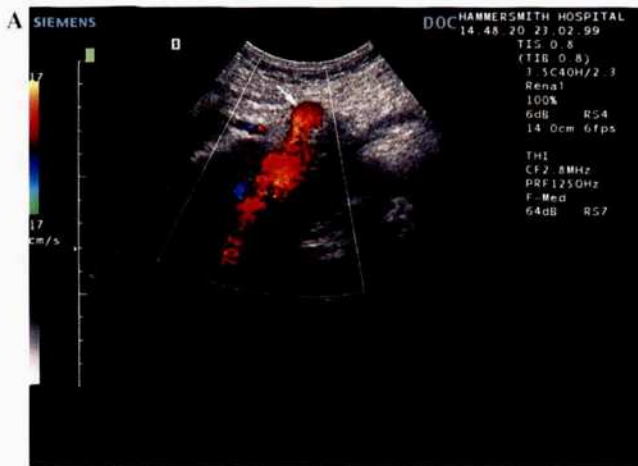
Recanalized umbilical vein. Recanalization of the umbilical vein produces this spectacular appearance on the color Doppler, with signals in the position of the ligamentum teres (arrow in A) flowing toward the umbilicus (U in B) and sometimes, as in this patient, on down into the pelvis [the change from red to blue codes for a relative change in flow direction, which is toward the probe superiorly (A), then parallel (B), and finally away from it (C)]. Often this spontaneous portosystemic shunt depressurizes the system and there are no other features of portal hypertension, such as ascites.
